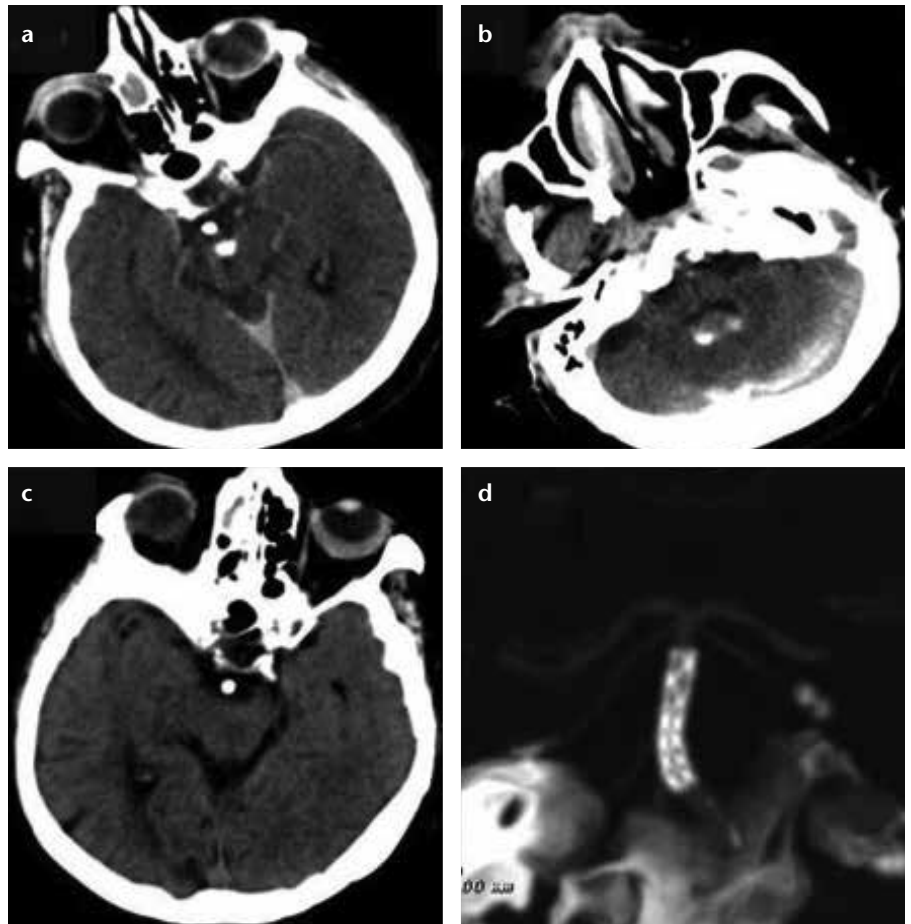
a–d. Postoperative axial CT images (a, b) show hemorrhage and contrast media in the interpeduncular fossa and fourth ventricle. Control CT image (c) shows no blood and hydrocephalus. First month control CT angiography thick-reformatted image (d) displays good stent apposition and patency of the artery and side branches.
